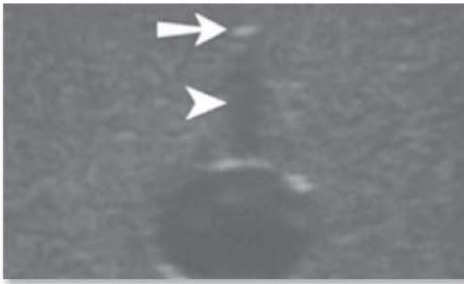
In this ultrasound image showing the transverse approach to IV placement, the needle tip appears as a single bright dot (arrow); posterior shadowing (arrowhead) helps to identify the tip
